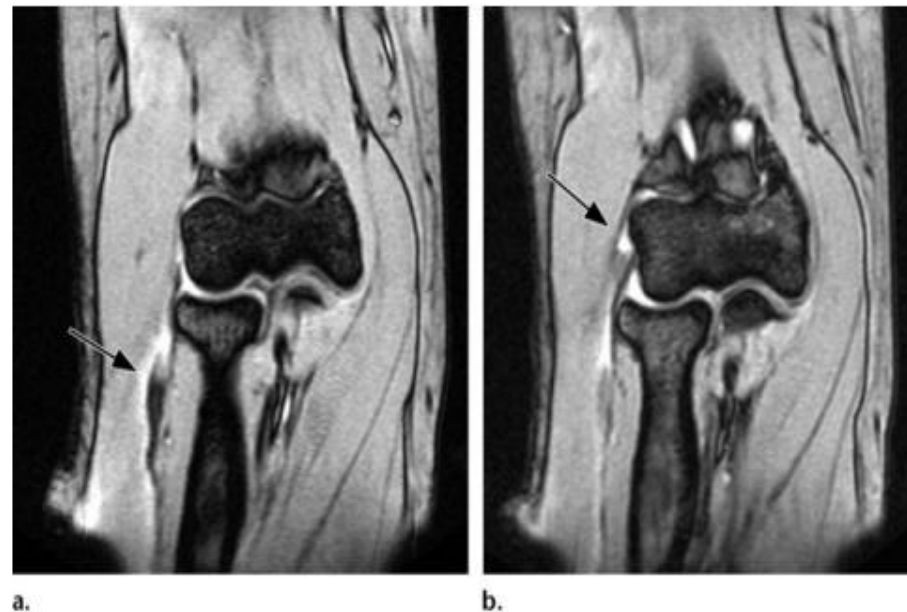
Severe lateral epicondylitis. (a) Coronal GRE MR image obtained in a 40-year-old woman demonstrates a full-thickness tear and retraction of the ECRB with adjacent edema (arrow). (b) Coronal GRE MR image at the level of the lateral epicondyle shows a fluid-filled gap (arrow) at the site of the expected ECRB tendon origin.
